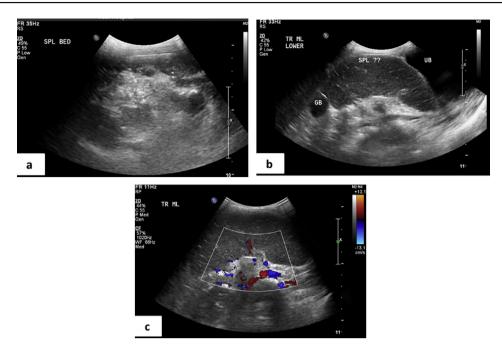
Ultrasound images of the abdomen and pelvis show (a) absent spleen in the left hypochondrium. Avascular wandering spleen in the right lower abdomen (b, c).
